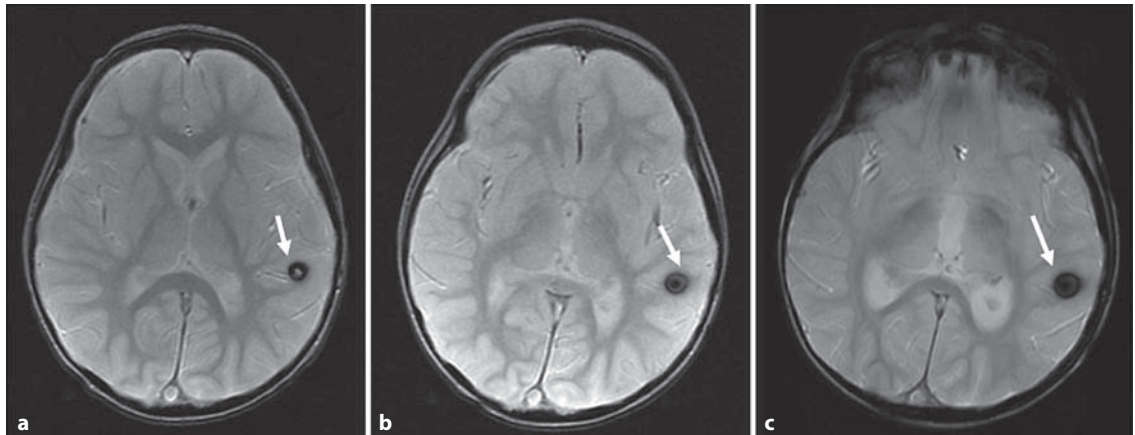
MRI of brain T₂-weighted axial gradient echo sequence. a At diagnosis. b After 3 months of therapy with bevacizumab. c After 6 months of bevacizumab therapy. Persistent signal abnormality despite resolution in conventional MRI sequences.
